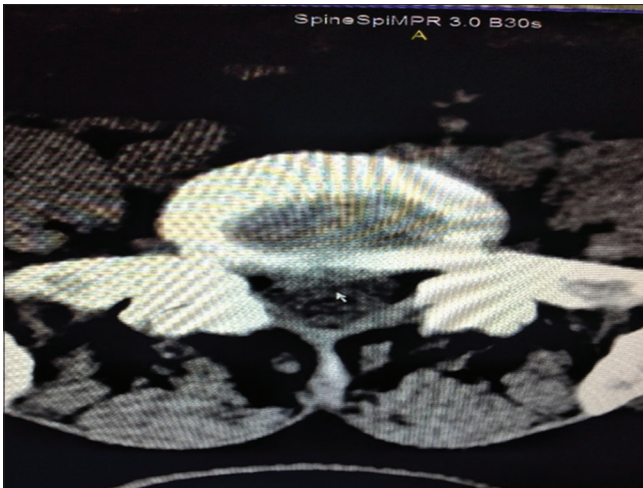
Patient with the lower back and right lower leg pain. The CT scan shows right medio lateral herniated disk Grade I in the L4-L5 intervertebral space
